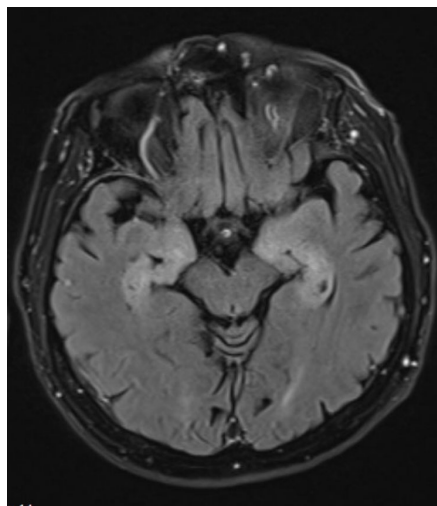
FLAIR sequence. Hyperintensities in the subcortical white matter, involving the medial temporal lobes bilaterally.
